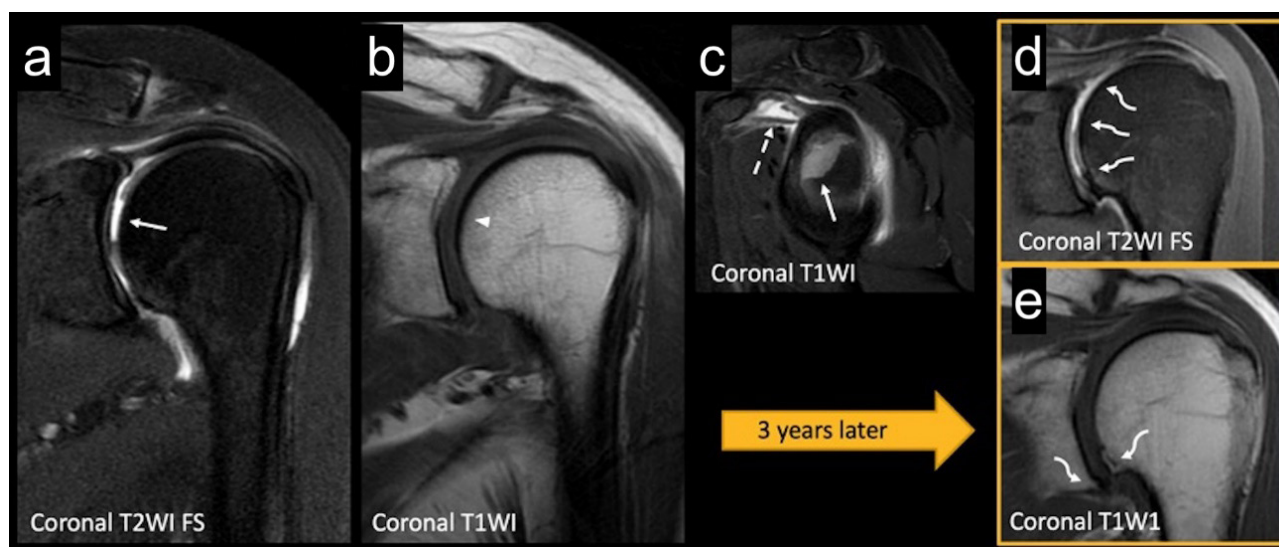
A 59-year-old female patient who presented with severe left shoulder pain after physical activity. (A–C) MRI scans showing a focal chondral lesion in the humeral head (arrows), without subchondral signal alterations (arrowhead). A chondral fragment was detected in the subcoracoid recess (dashed arrow). (D,E) Three years later, diffuse chondral thinning and osteophytes were observed (curved arrows).
